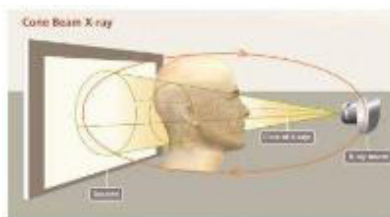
X-ray beam projections on CBCT where the opposite flat-panel source and detector rotate around the patient’s jaw to capture image data in a single loop (Alamri et al., 2012).
